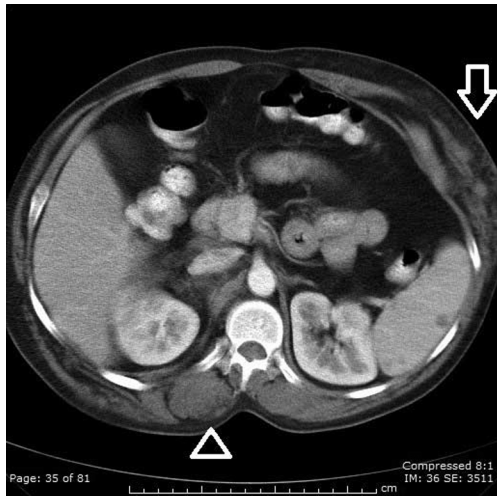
Proteus Syndrome in a 26-year-old male. Axial CT. The asymmetry of the paraspinal muscles is thought to be due to deposition within the muscles (open arrowhead). Note soft-tissue infiltration of the left anterior chest wall (white open arrow), as well as nonspecific, low-density lesions in the spleen.
